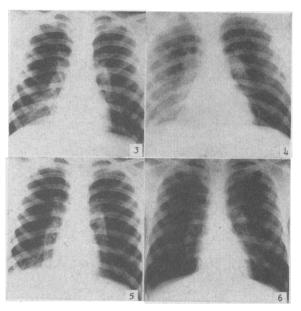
December 8, 1943—Early in the course of the disease. Fig. 4.—December 17, 1943—At the time of maximum chest findings. Fig. 5.—January 12, 1944—Chest clear to auscultation. Patient convalescent. Some residual findings on x-ray. Fig. 6.—January 11, 1945—One year later showing normal chest.
